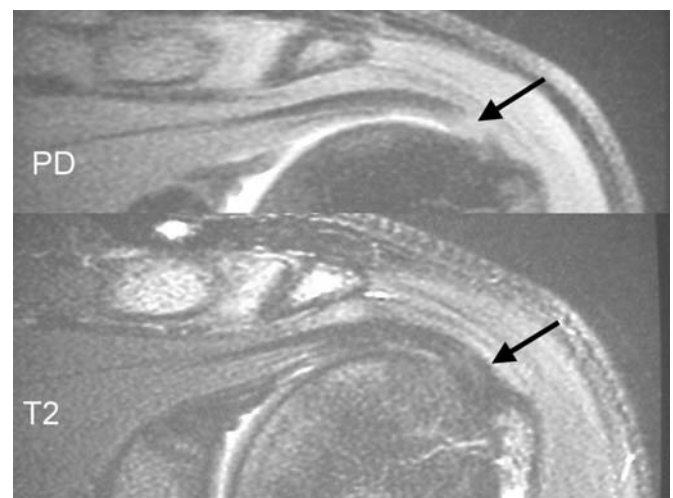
Coronal proton density (top) and T2 (bottom) MRI of the left shoulder. Magic angle artifact seen on PD is cancelled out on T2 (arrows).
